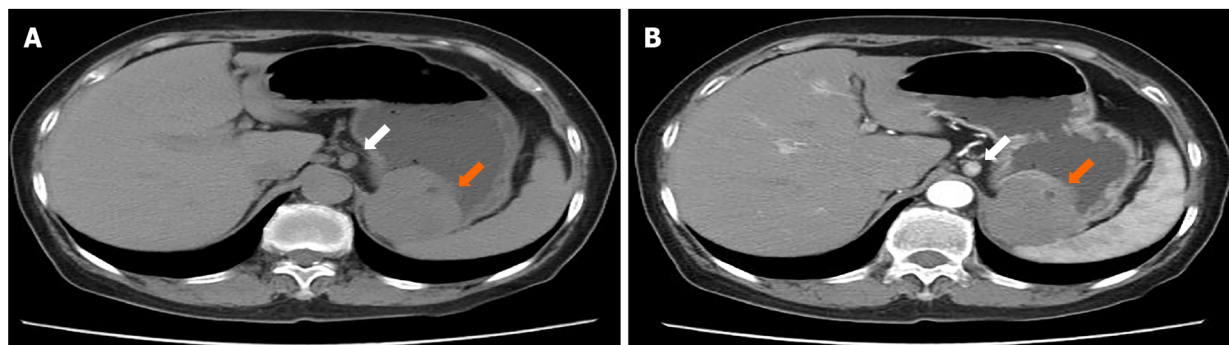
Abdominal computed tomography plain scan and enhancement. A: Plain computed tomography (CT) showed a local soft tissue density mass in gastric wall (orange arrow), smooth boundary, local protrusion outside the contour of the stomach, with surrounding enlarged lymph nodes (white arrow); B: Enhanced CT showed a markedly enhanced mass (orange arrow), with surrounding enlarged lymph nodes (white arrow).
